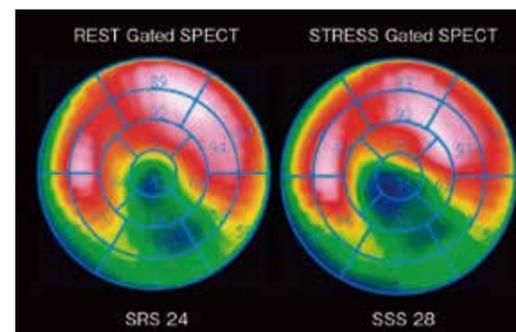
SPECT images of the same patient as in Figure 2.
